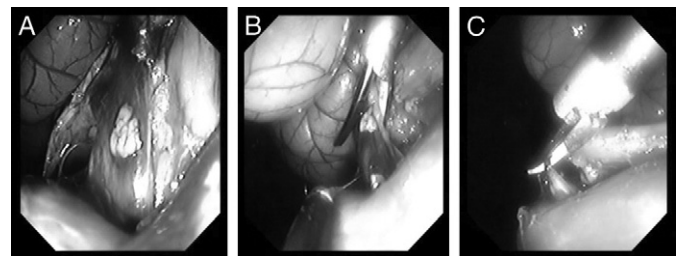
Gastroscopic image demonstrates renal vein ultrasonic ligation. A, dissected vein. B, starting ligation. C, finishing ligation.
